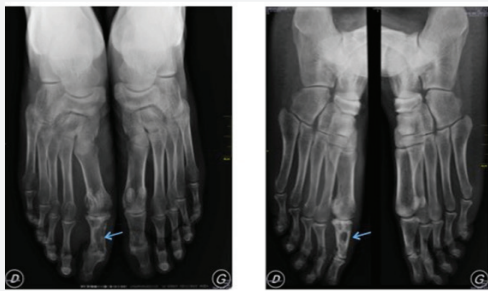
Radiography of the frontal and posterior feet: Bone luminosity with sharp, regular and opaque contours in the first phalanx of the first ray of the right foot. Thickening of the cortical bone of the 1st phalanx and the head of the right 1st margin.
